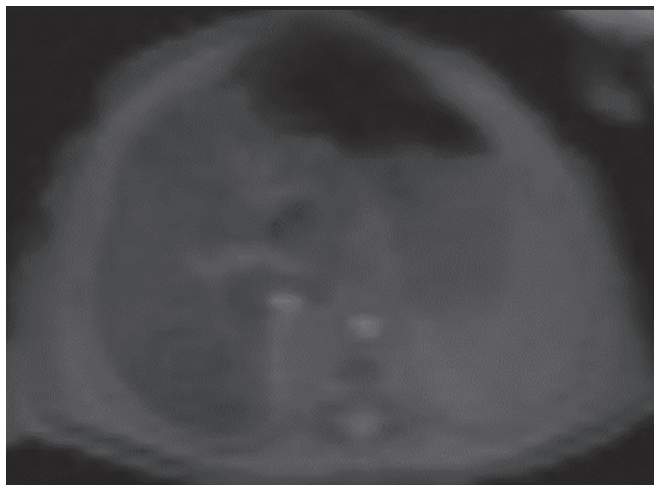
(Image 2): Magnetic resonance imaging of the abdomen on day 3 of life shows moderate-to-severe iron load in the liver with mild pancreatic iron overload. Liver iron TE 12.27 ms
